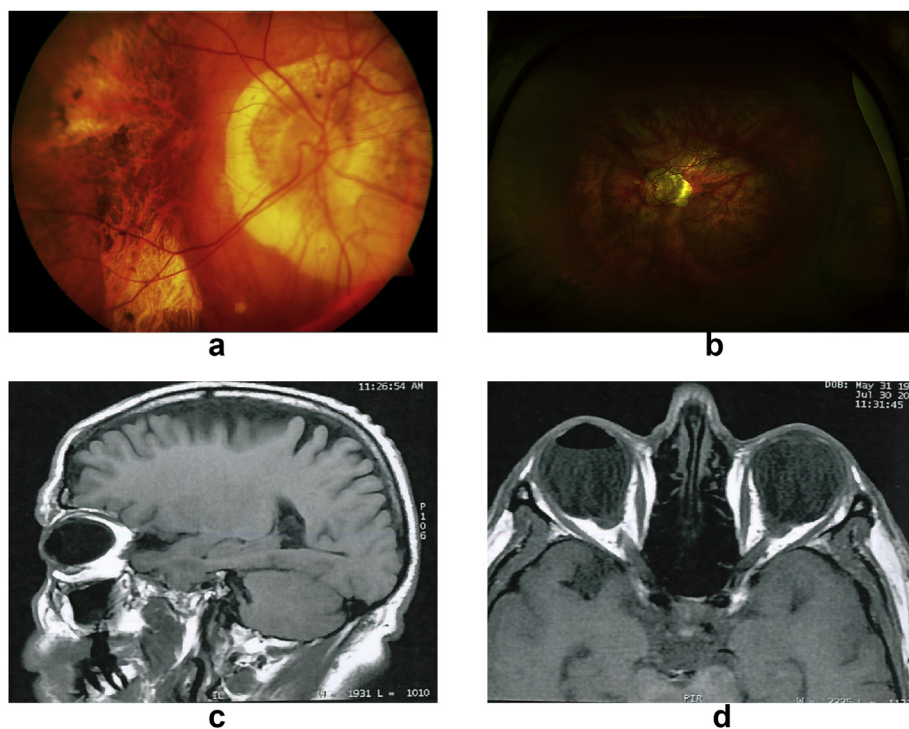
Vertical posterior staphyloma in a highly myopic eye with marked RPE and chorioretinal atrophy (a). 34-year-old highly myopic patient with a posterior staphyloma, after scleral buckling surgery (b). Magnetic resonance imaging of an aphakic highly myopic patient after left eye retinal detachment surgery, showing intraocular gas in the anterior chamber and posterior staphyloma (c, d).
